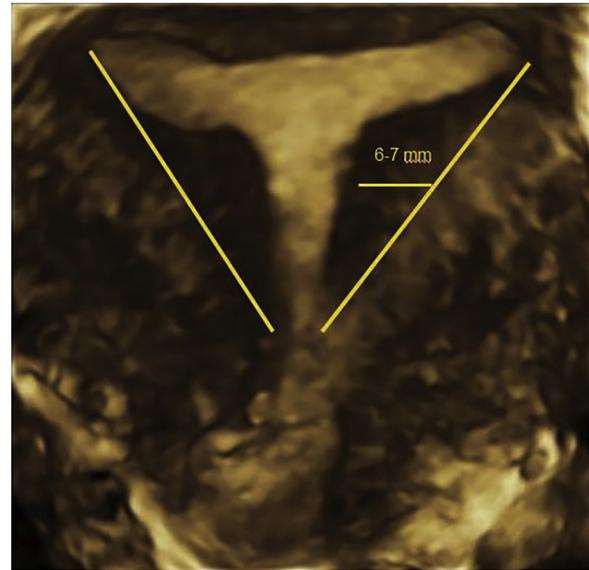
Measurement of the uterine wall thickness is defined as the distance between the interstitial line and external uterine profile at the mid-coronal plane of the uterus obtained with transvaginal 3D ultrasonography; as clearly showed in the Figure, the external uterine contour and the length of any existing internal indentation (defined as the distance between the interstitial line and the indentation's edge at the cavity) should be always clearly delineated for a proper diagnosis.
